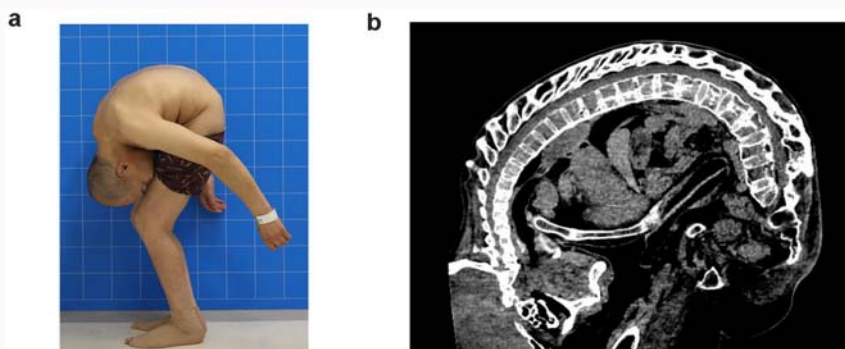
a) Shown the lateral view of the patient. b) Shown the sagittal CT examination, which can see that L3-L5 vertebral compressed and flattened, aortic tortuosity, thoracic aorta, bilateral common iliac artery slightly hardened; ankylosing spondylitis accumulates bilateral sacroiliac joint and hip joint; an old fracture of the 10th rib on the right side.
